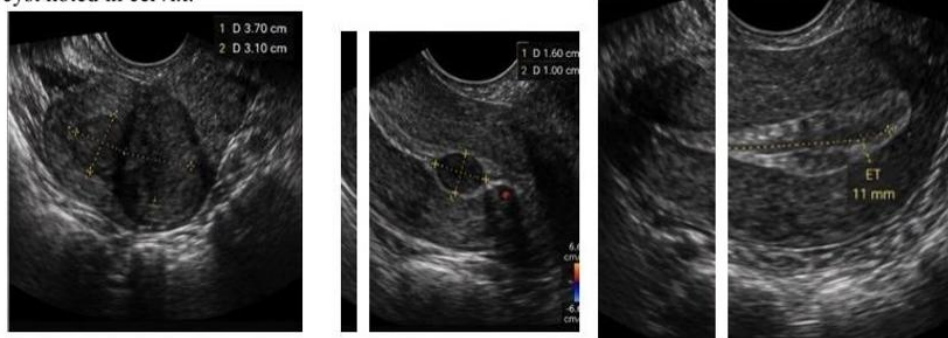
Transvaginal ultrasonography showing intramural leiomyomas (3.7 x 3.1 cm and 1.5 x 1.1 cm), cystic endometrial change, and a focal hypoechoic endometrial lesion (1.6 x 1.0 cm) with minimal vascularity.
